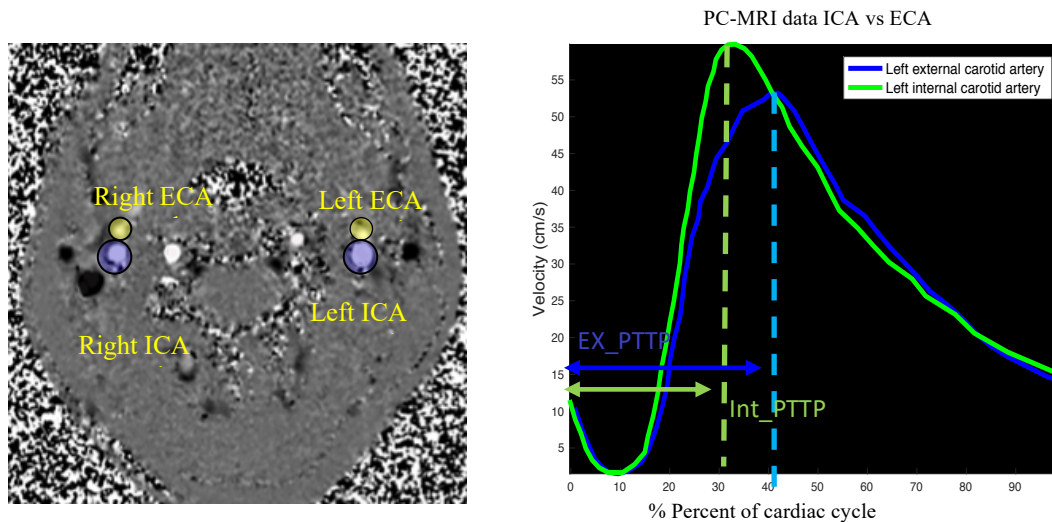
Left: Example of a transverse slice extracted from PC-MRI data showing left ICA, right ICA, left ECA, right ECA. Right: Velocity waveforms for left ECA and left ICA for one participant. As we can see there is a time delay between the peaks in ICA versus ECA.
